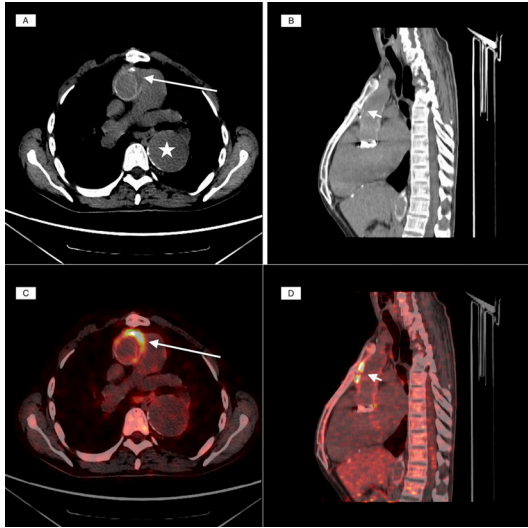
Axial (A) and sagittal cuts (B) of CT of the chest failed to identify any periaortic infection. Prosthetic aortic valve and graft extending till descending thoracic aorta can be seen (white star). Corresponding positron emission tomography cuts showing periaortic, vascular graft infection in axial (C) (long white arrows) and sagittal cuts (D) (short white arrows).
